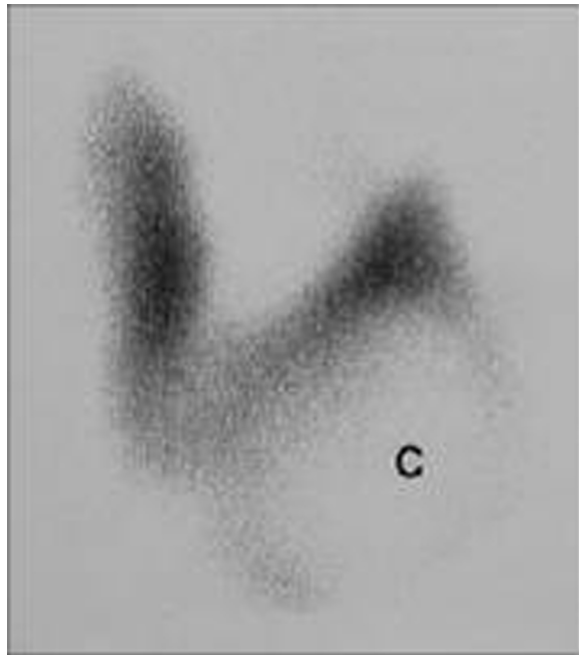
Large 'cold nodule' marked 'c' replacing and displacing the lower pole of the left lobe of the thyroid in a 55-year-old woman. Subsequent ultrasound and fine needle aspiration confirmed a simple colloid cyst.
